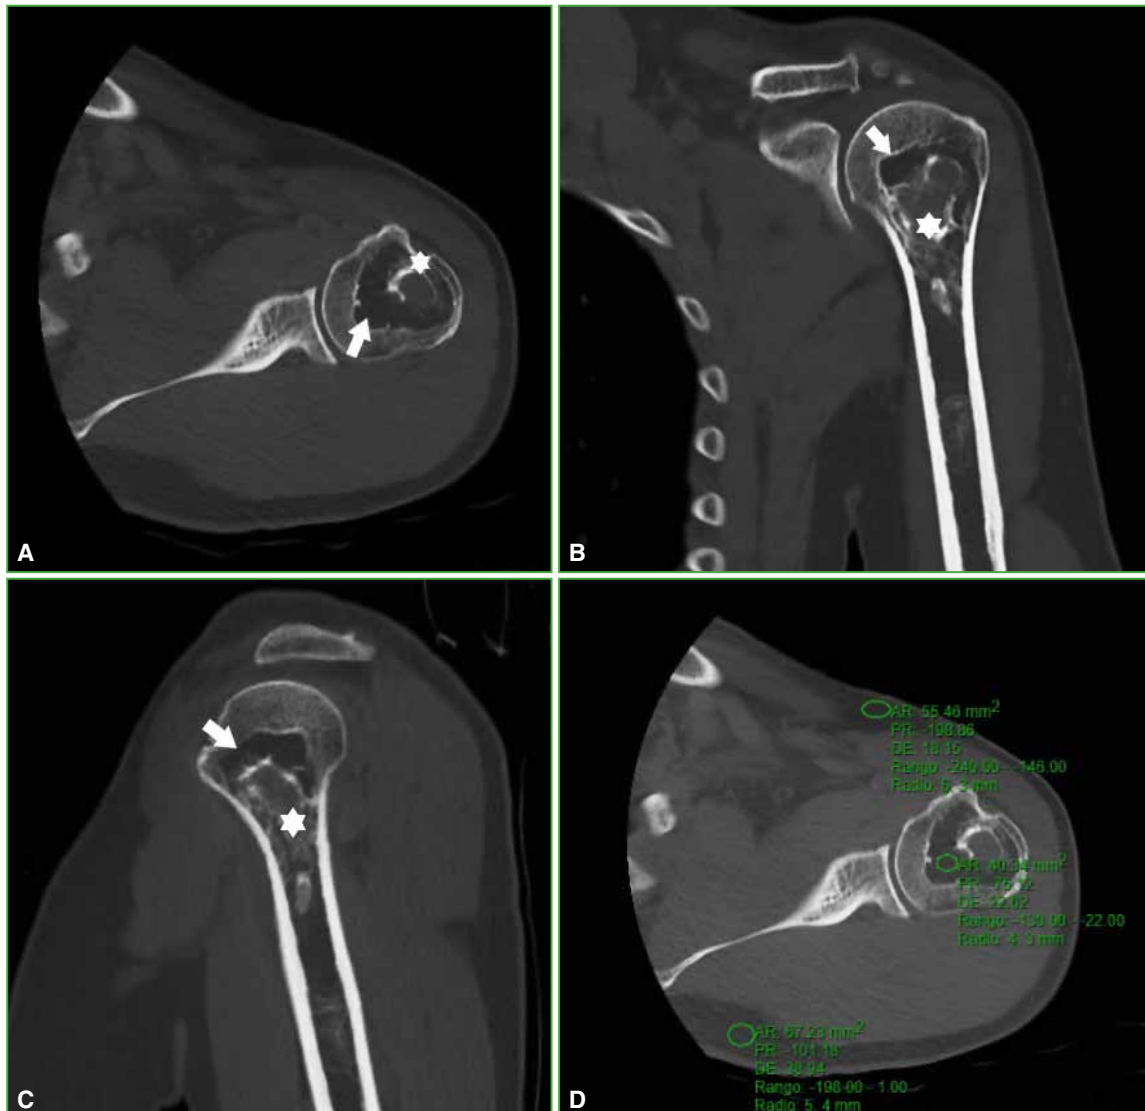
Computed tomography of the left shoulder. A. Axial section in bone window. Heterogeneous lesion that alternates hypodense (arrows) and hyperdense (asterisk) areas. B and C. Coronal and sagittal sections, respectively, in the bone window. A hypodense lesion (arrow) with its hyperdense central component (asterisk) without endosteal cortical invasion. D. Axial section in bone window where measurements of the Hounsfield Units (HU) of the lesion are made, which yield a value of -75 HU (compared with the TCS, with an average value of -150 HU).
